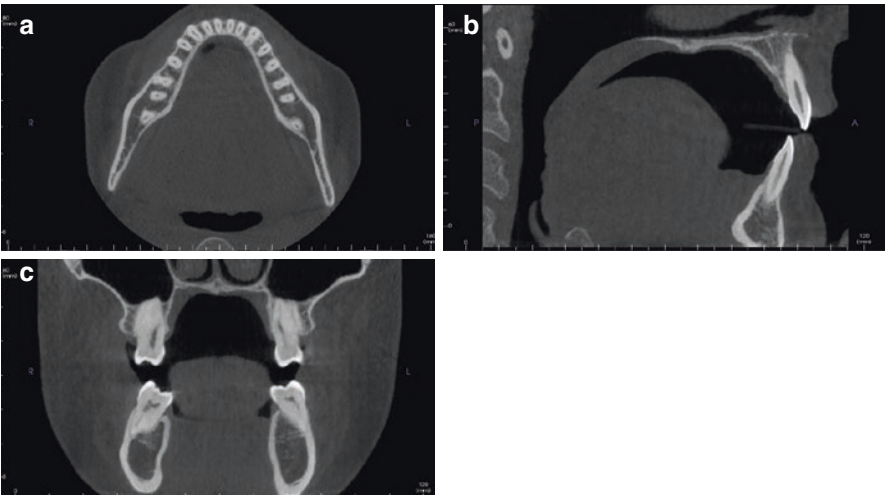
Cone-beam computed tomography images in the multiplanar view (MPR), obtained using a medium field of view. (a) Axial view showing the mandibular arch. (b) Sagittal view showing the central incisors. (c) Coronal view in the area of the molar teeth
